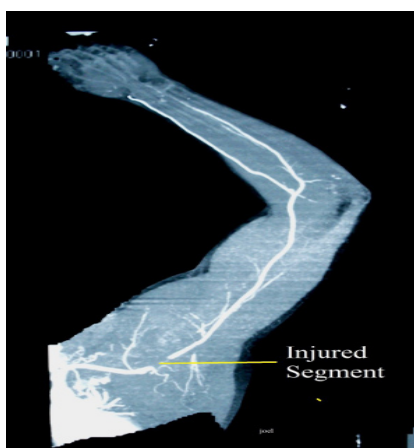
Computed Tomographic Angiography showing the injured segment
